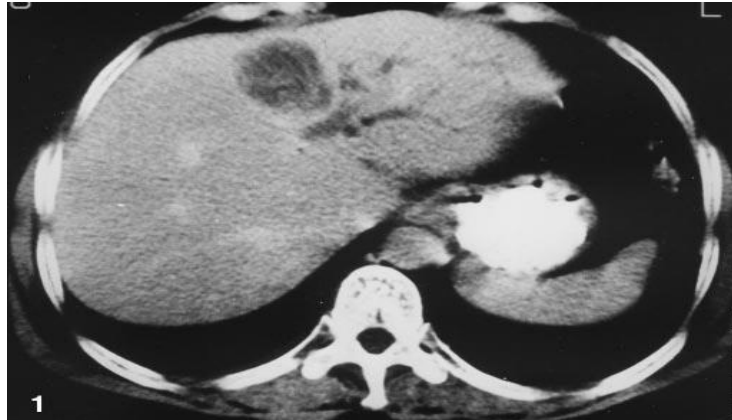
Disparity-heightened CT scan of liver displays the hydatid cyst together with widened leftward hepatic duct, signifying disagreement into biliary scheme.
